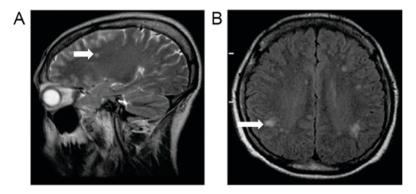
MRI scan of the patient. (A) T2-weighted image and (B) fluid attenuated inversion recovery MRI scan of the brain exhibiting bilateral, multifocal hyperintense lesions (white arrows) in the white-matter of the frontal (left) and parietal (right) lobes. MRI, magnetic resonance imaging.
